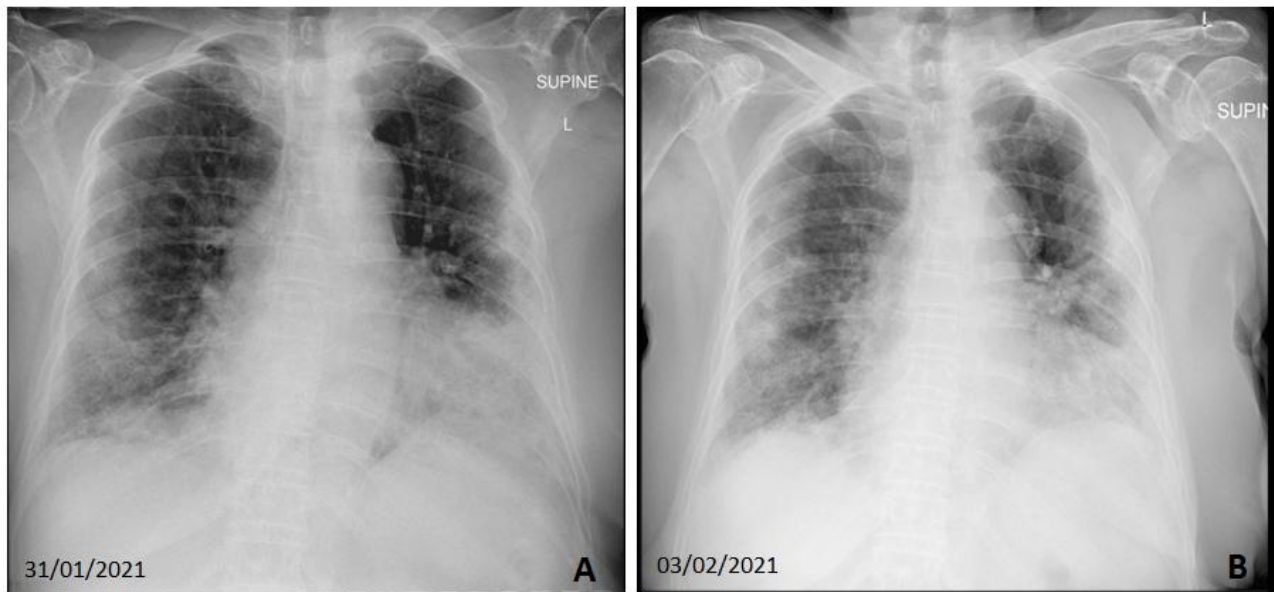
Serial chest x-rays after admission, show worsening bilateral pulmonary opacities possibly obscuring the border of the diaphragm on the left. A – 4 days after admission, B – 7 days after admission
